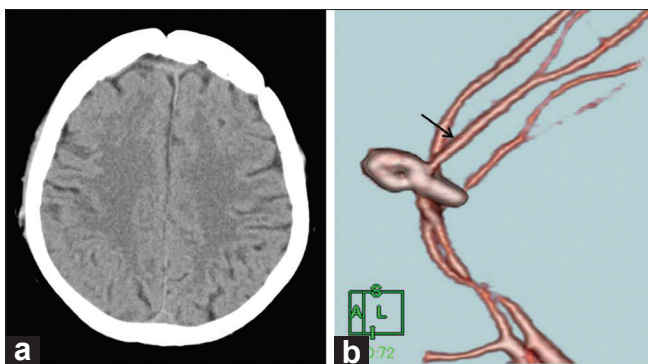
Postoperative computed tomography scan and 3-dimensional CT angiography. (a) Computed tomography scan after operation showing no ischemic lesion in the left anterior cerebral artery territory. (b) The oblique view of postoperative 3-dimensional CT angiography showing elimination of the aneurysm and good recanalization of the left callosomarginal artery (arrow)
